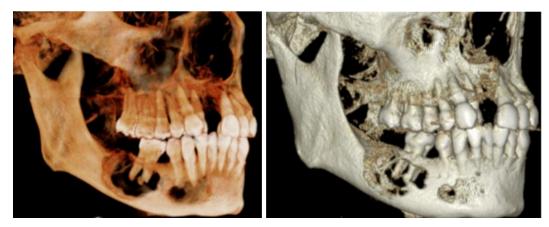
Three-dimensional (3D) reconstruction of CBCT, buccal teeth view (left) and bone view (right)
